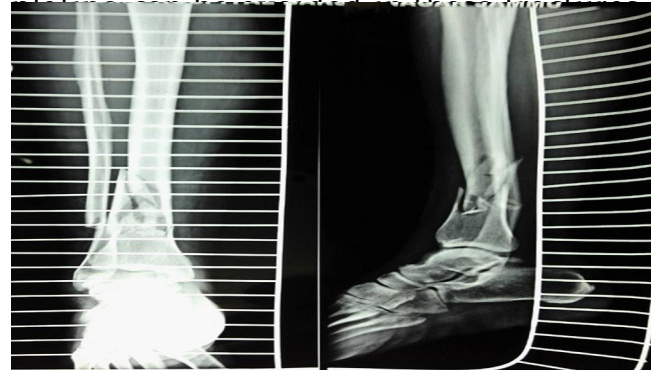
(a). PreOp Radiograph of patient showing comminuted extraarticular fracture tibia with fractured fibula.
